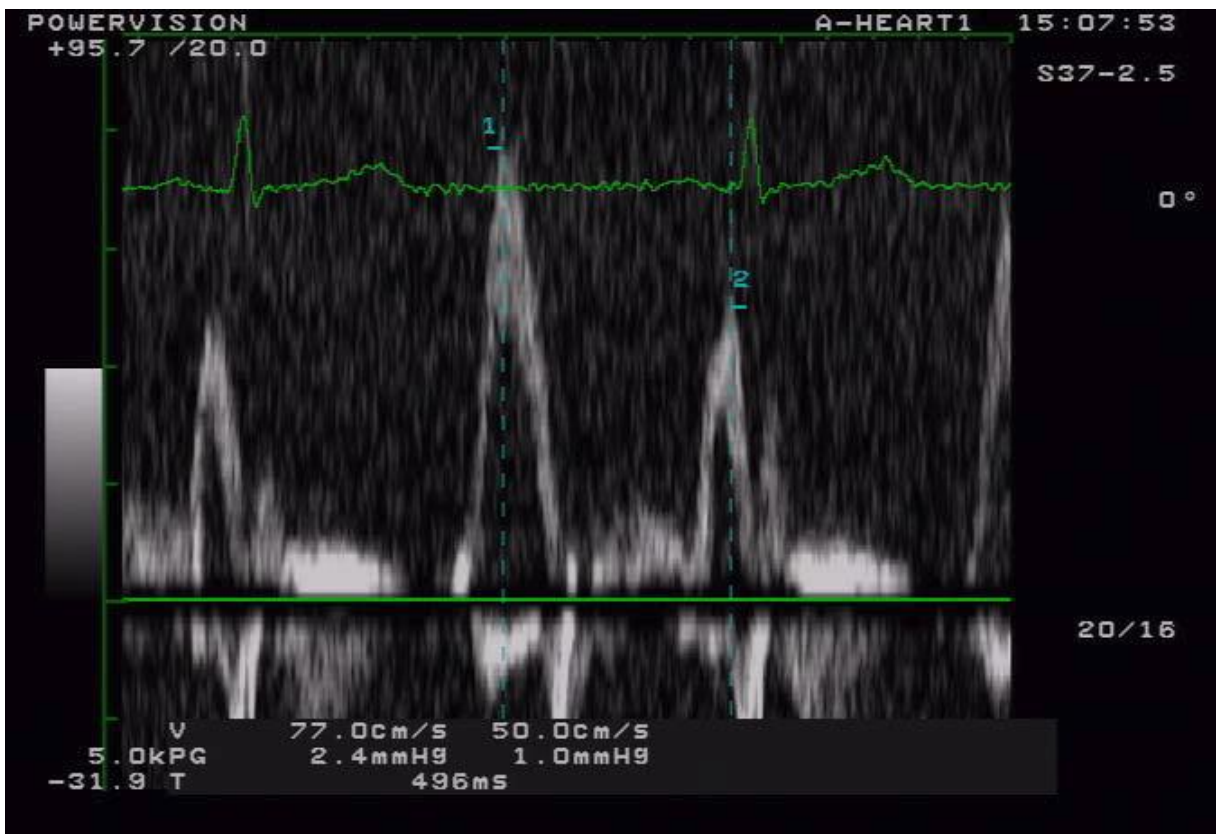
PW Doppler flow over the mitral valve, measurement of the E-wave Vmax (77.0 cm/s) and A-wave Vmax (50.0 cm/s) [31], E/A ratio= 1,54, which would correspond to moderate diastolic dysfunction if the LA_Vol_i ≥34ml/m², see Figure 11.
